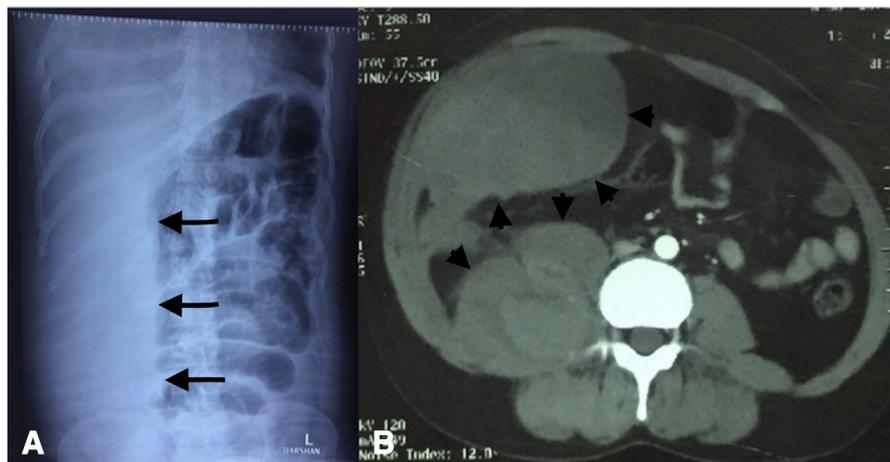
(A) Plain x-ray study of the abdomen showing the shifting of bowel loops (arrows) toward the left side (half and half abdomen sign). (B) Computed tomography of the abdomen images showing a large hematoma anteriorly on the right side (13 × 8 × 5 cm) along with two retroperitoneal hematomas (arrowhead) (largest diameter 7 and 5 cm, respectively), displacing the gut loops toward the left side.
